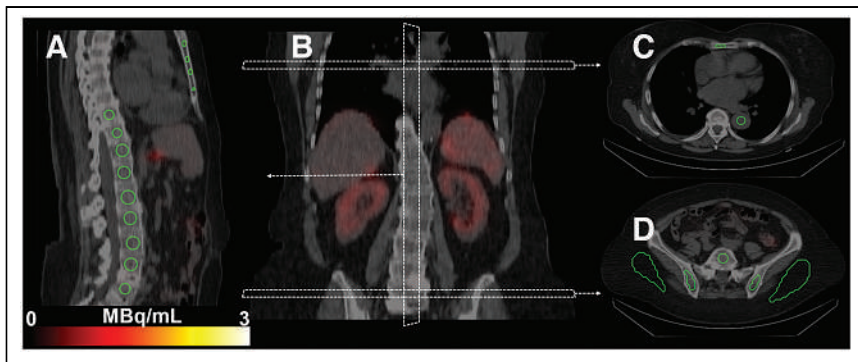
SPECT/CT images from patient 14 show delineated VOIs (green contours). (A) Sagittal view of delineated T9–L5 vertebrae and sternum. (B) Orientation and position of each image slice in coronal plane. (C) Transverse slice of descending aorta and sternum. (D) Hypogastric and iliac regions and delineations of L5 vertebrae, left and right hip bones, and subcutaneous adipose tissue.
